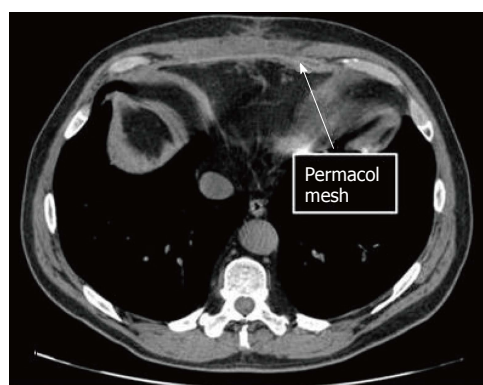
Computed tomography scan at 6 mo after abdominal wall repair. Arrow: Biological prosthesis.
